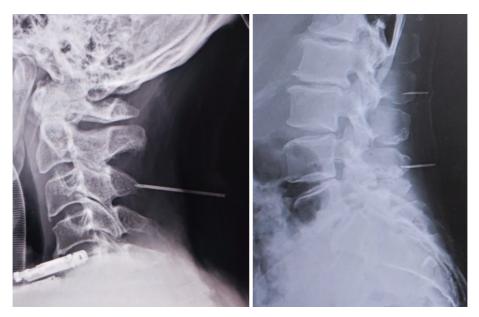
Confirmation of the level using radiographical markers.
